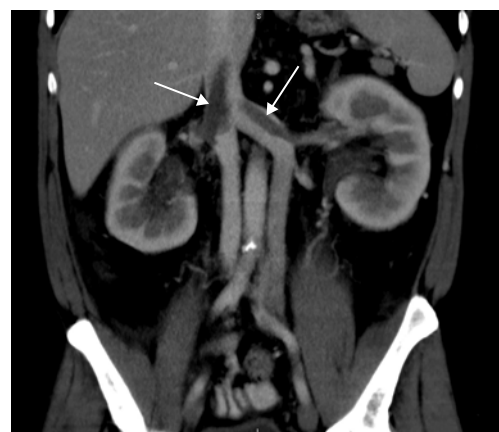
Computed tomography scan, coronal plane. The arrows show branches of the duplicated inferior vena cava with bilateral vein thrombosis. Thrombosis within the duplicated inferior vena cava extends to both renal veins.
